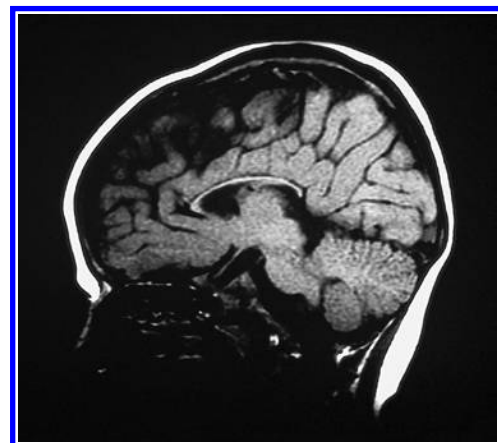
Magnetic resonance image of the brain of the same patient at 23 months. By this time, there was extensive paucity of myelination and diffuse atrophy. The corpus callosum was very thin. Neurologic progression occurred despite therapy with hydroxocobalamin. (Images were kindly provided by Dr GM Enns of Stanford University.)
